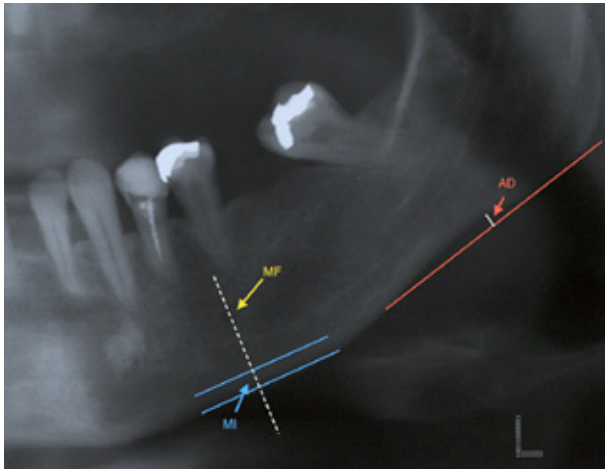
A cropped panoramic radiograph showing the MI and AD measurements.
